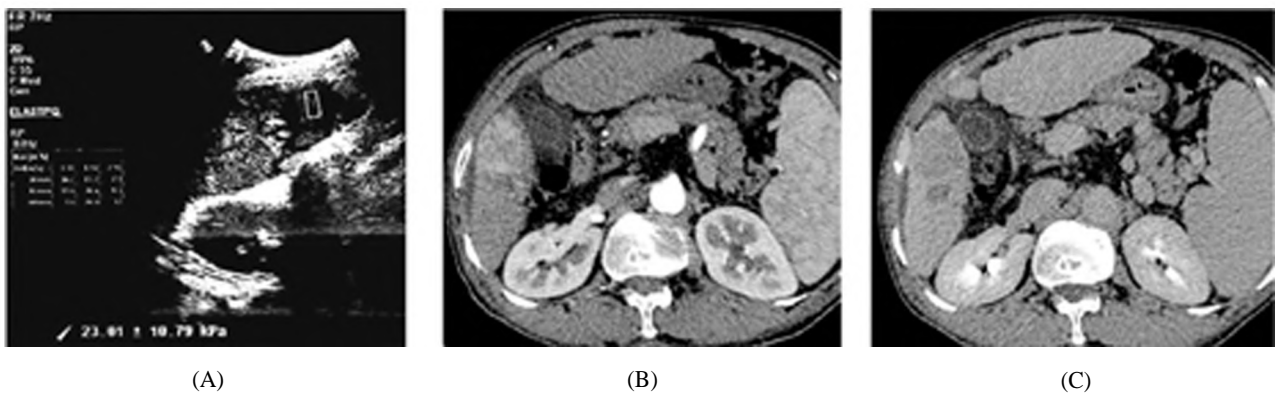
Hepatocellular carcinoma on top of liver cirrhosis. 50 year old male presenting with past history of liver cirrhosis and elevated AFP (A) B-mode shows a well-defined hypoechoic focal lesion at segment V with SWE mean stiffness value (23 ± 10 kpa). (B-C) Axial Triphasic CT, arterial phase (B), delayed phase (C), which shows enhancement in the arterial phase and contrast washout in the delayed phases.
